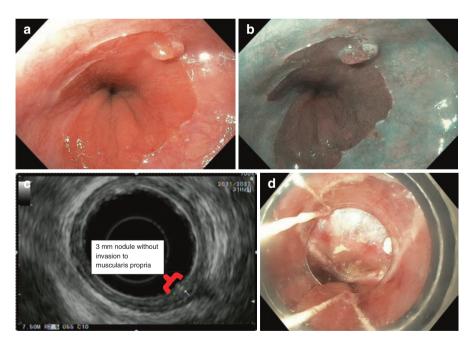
Endoscopic staging of T1a esophageal adenocarcinoma. (a) 3 mm nodule at Z-line. (b) The same lesion visualized under narrow band imaging. (c) Endoscopic ultrasound showing the lesion limited to the mucosa. (d) Endoscopic mucosal resection (EMR) of the lesion. The pathology results revealed intramucosal adenocarcinoma with 4 mm negative margins. In this case the EMR was therapeutic as well as diagnostic
